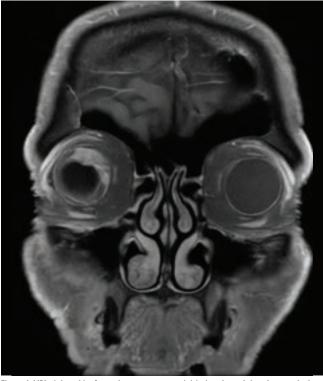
MRI of the orbits 3 months post-treatment initiation showed that the mass had decreased by more than half.
